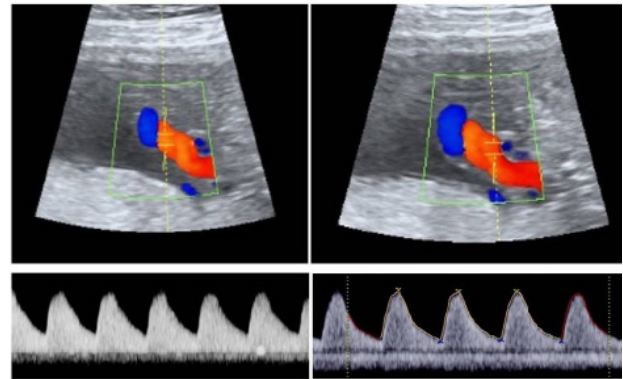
Measurement the paired umbilical artery Doppler.
